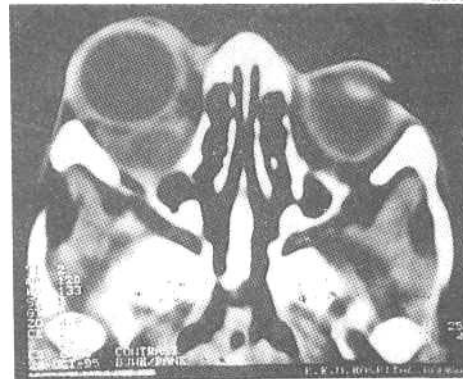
Orbital CT scan showing retrobulbar pseudotumor. The media are clear.
